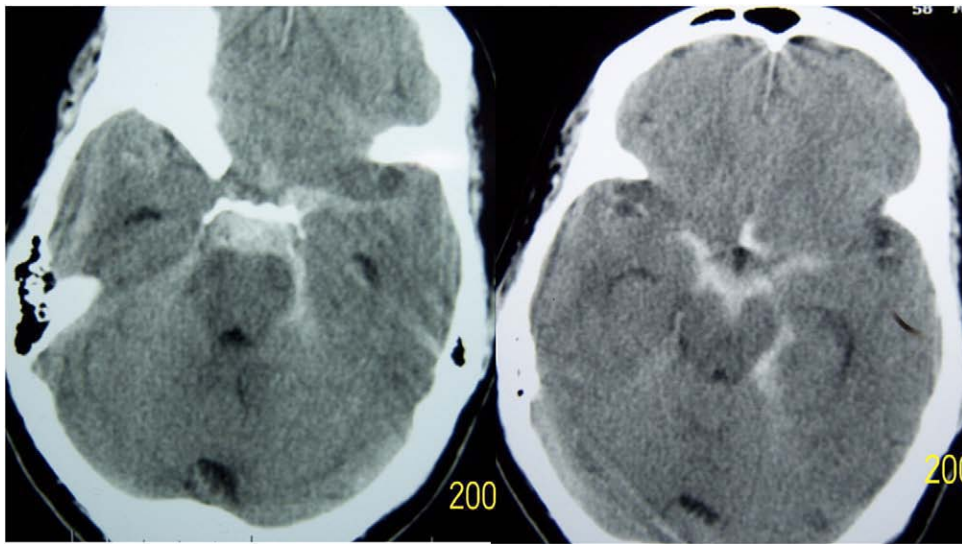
Computed tomographic scans of 2 patients with PMN SAH.
